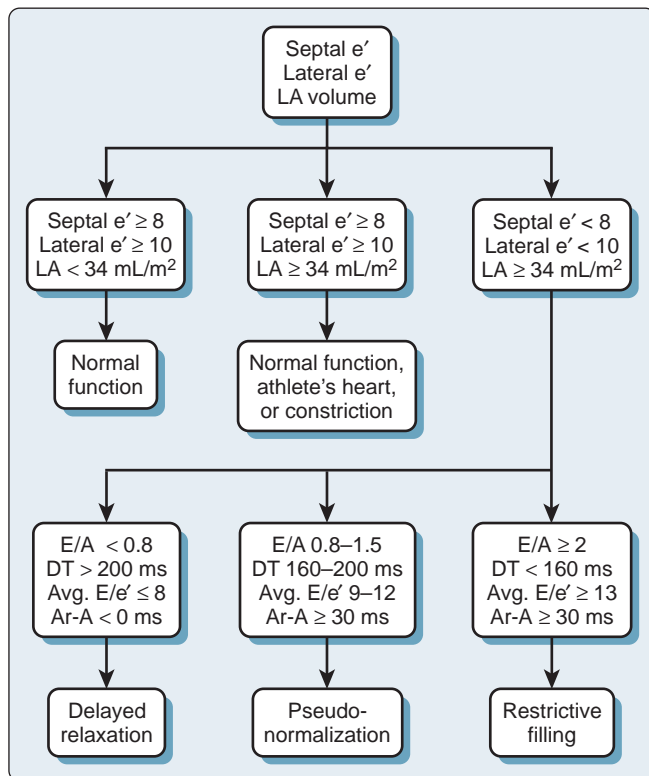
Classification of diastolic dysfunction. A, Late diastolic transmitral velocity; Ar-A, difference between pulmonary venous atrial reversal duration and transmitral A-wave duration; DT, E-wave deceleration time; E, early diastolic transmitral velocity; e', early diastolic tissue Doppler velocity; LA, left atrial.
